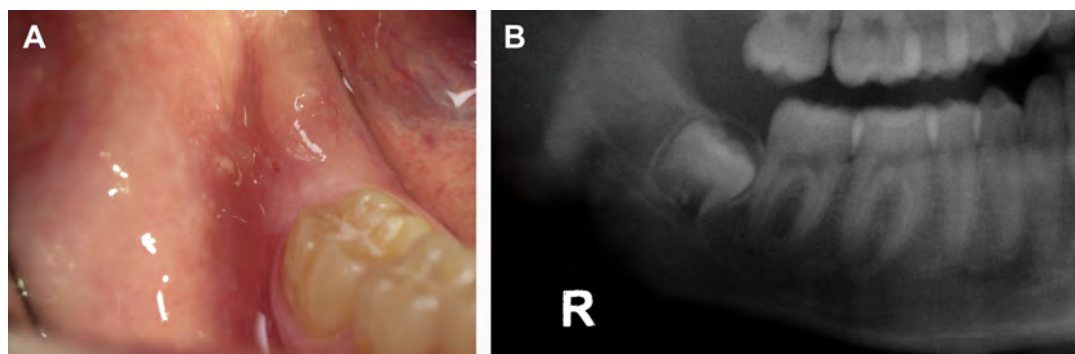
(A) Complete bone impacted mandibular third molar. (B) Radiograph of complete bone impacted mandibular third molar.
